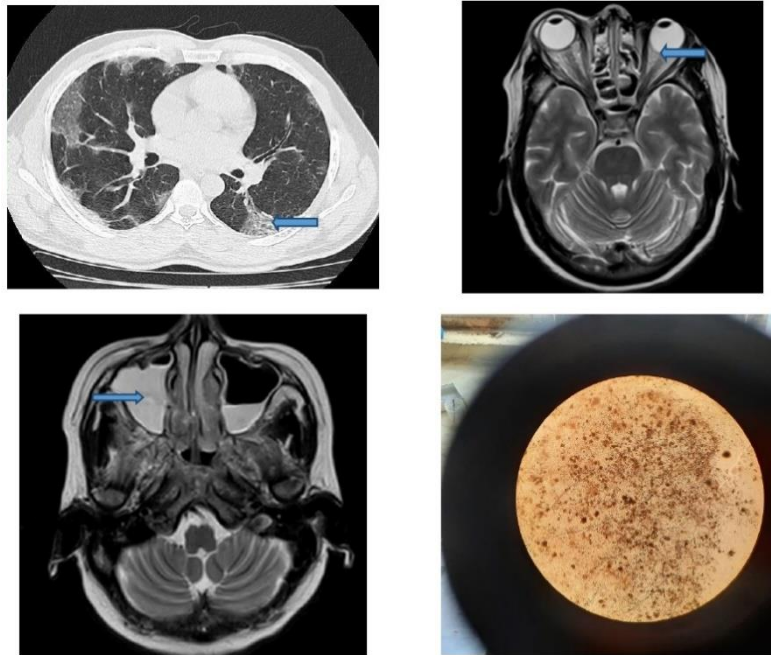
65 years male CT chest: diffuse bilateral GGO (periphery), MRI: Mild right orbital proptosis. Moderate edema in intra and extraconal space of the right orbit with associated thickening of right extraocular muscles. Subtle edema in extraconal space of left orbit around the left inferior rectus muscle. Above findings are in favour of sino nasal fungal infection with bilateral orbital cellulitis R > L. Koh mount: Fungal elements are seen clearly.
